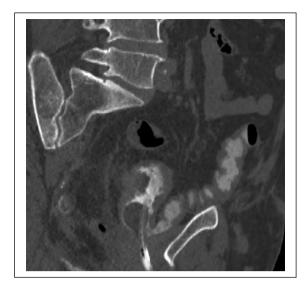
CT cystography showing a fistula between the distal antero-lateral side of the neobladder and the sigmoid, which was angulated and compressed between the neobladder itself and the pubic symphysis.
